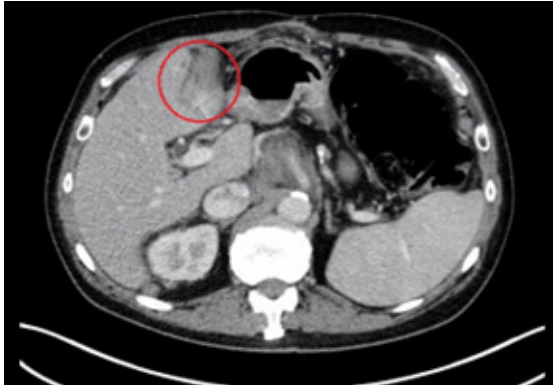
which shows the CT Abdomen taken 8 months later showing a decrease in the size of the left lobe lesion after Pemigatinib therapy.
